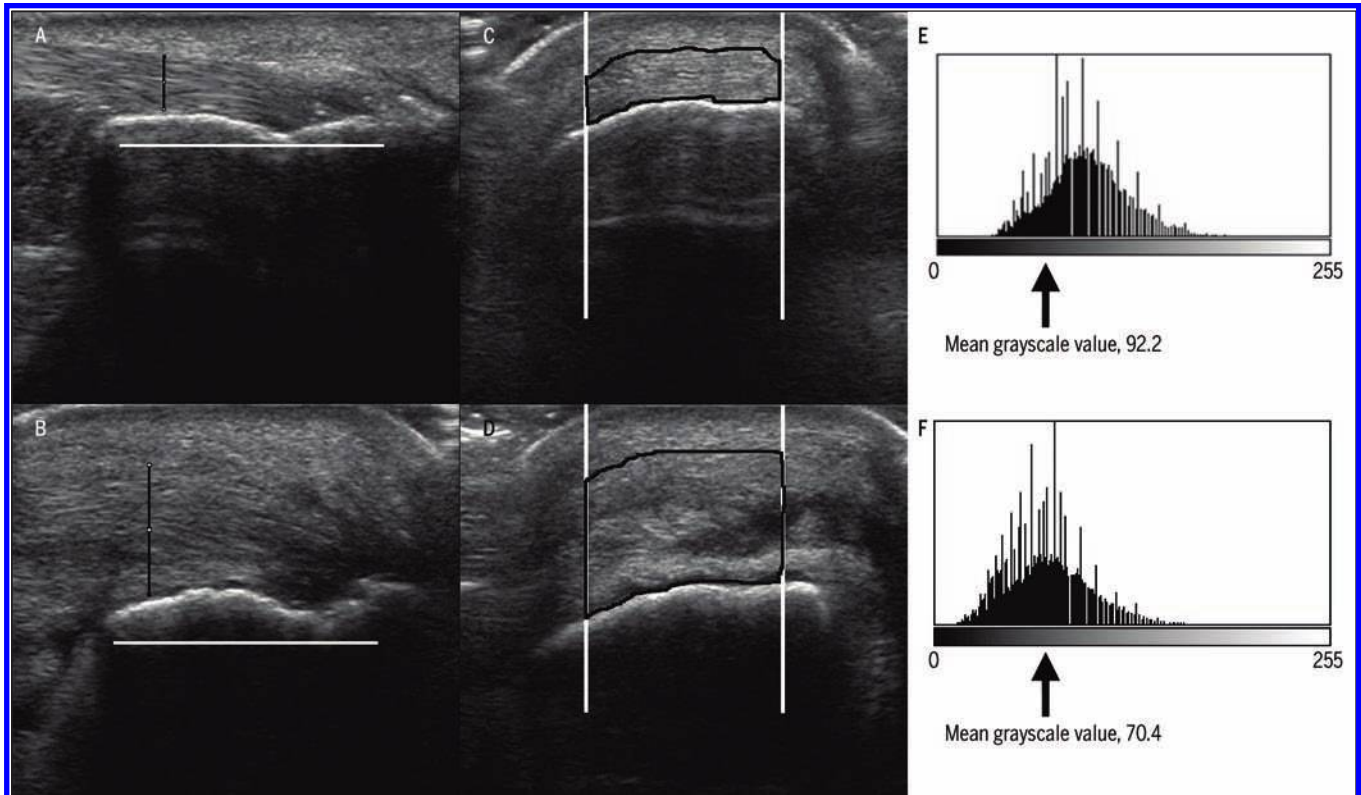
Tendon characteristics for uninvolved (top row) and involved (bottom row) sides of a participant with insertional Achilles tendinopathy. (A and B) Longitudinal ultrasound images of tendon diameter; (C and D) cross-sectional ultrasound images of echogenicity measured by the mean grayscale value; (E and F) corresponding histograms demonstrating the mean grayscale value (scale from 0, black to 255, white) for images C and D. A darker tendon results in a lower mean grayscale value, which indicates tendon degeneration.
